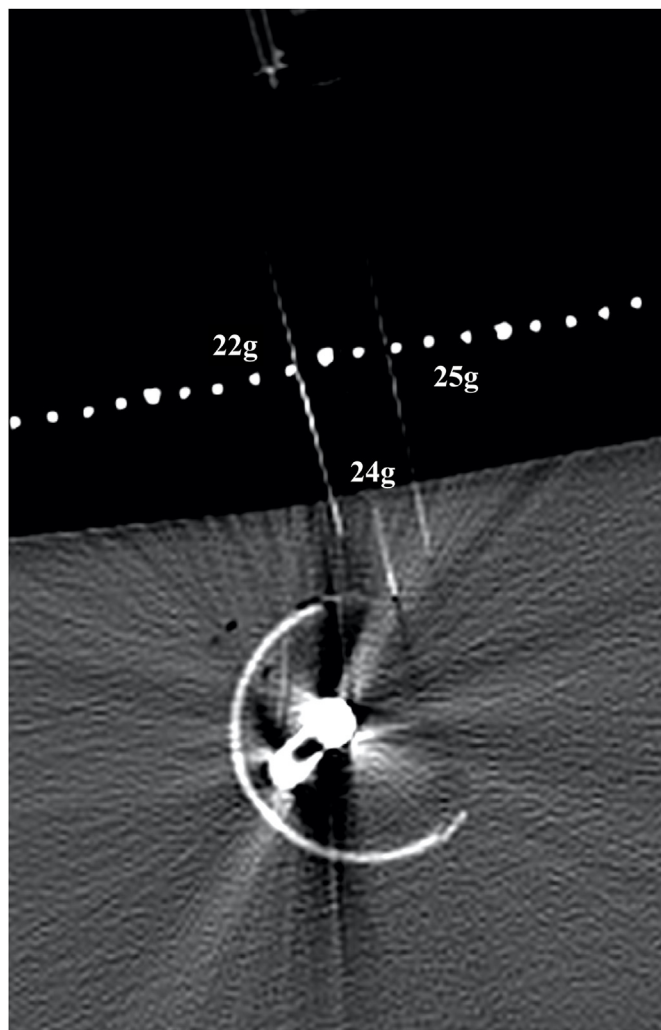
CT appearances corresponding to series 11 in Table 1. Settings were KV 100, mAs 2.5, slice thickness 1.2 mm, DLP 8.3 mGycm (low dose). There are prosthesis related and needle related artefact but it does not obscure the tip of the needle.
